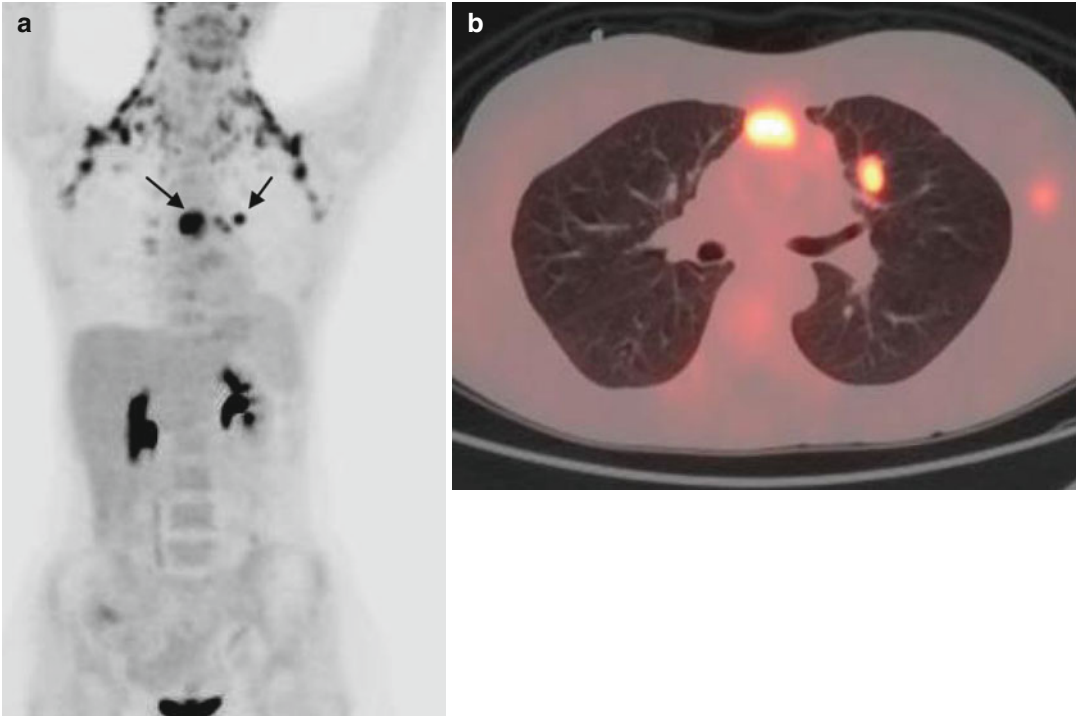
(a, b) MIP-PET and fused PET/CT after ASCT: Intense 18FDG uptake at the already known areas (mediastinum and *left* lung) (*arrows* in the MIP image).
